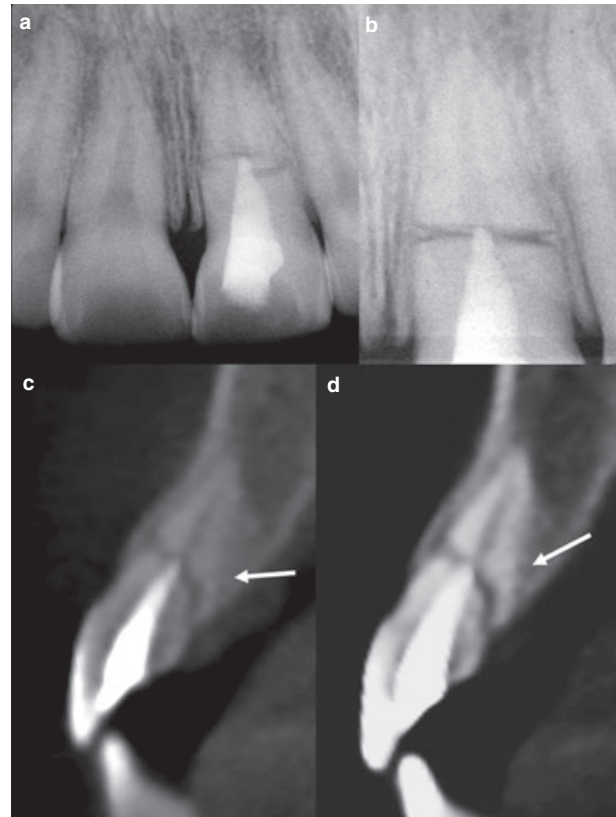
(a, b) At 10-month follow up the periapical radiograph shows evidence of root remodeling and a significant reduction of the fragments without interposition of granulation tissue. (c, d) NewTom images reveal only a slight reduction in the space between the fragments with interposition of bone and connective tissue. Lack of healing in the palatal surface of the root might be due to a double fracture of the root which can be seen in this cross-sectional proximal view (see arrow).
